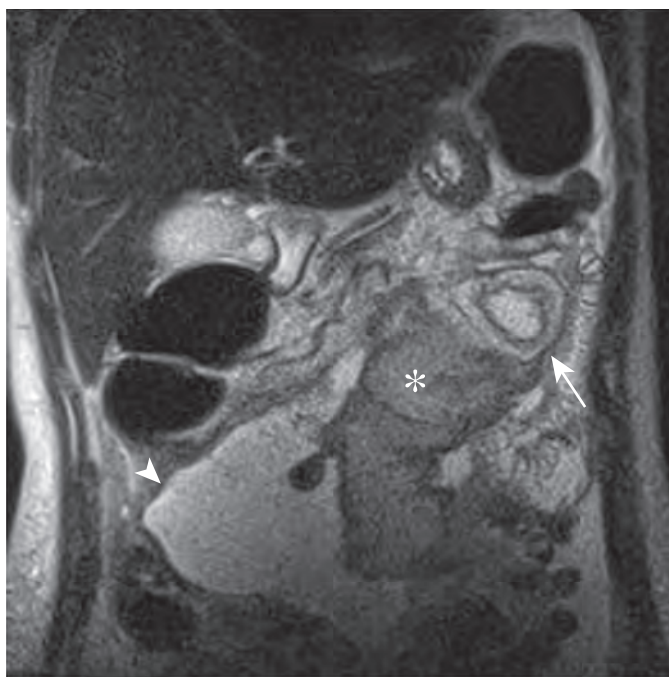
Pancreatitis with peripancreatic fluid collections in a 45-year-old woman after PAK transplantation. Coronal HASTE T2-weighted MR image shows a high signal fluid collection (arrowhead) surrounding and displacing the edematous transplant (asterisk) to the left and extending into the right lower quadrant. Note the wall thickening and edema of the adjacent bowel loop (arrow). The fluid collections eventually caused venous thrombosis and ultimately required explantation of the graft. (From Vandermeer F, Manning MA, Frazier A, et al: *Imaging of whole-organ pancreas transplants*. *RadioGraphics* 32:411–435, 2012.)
